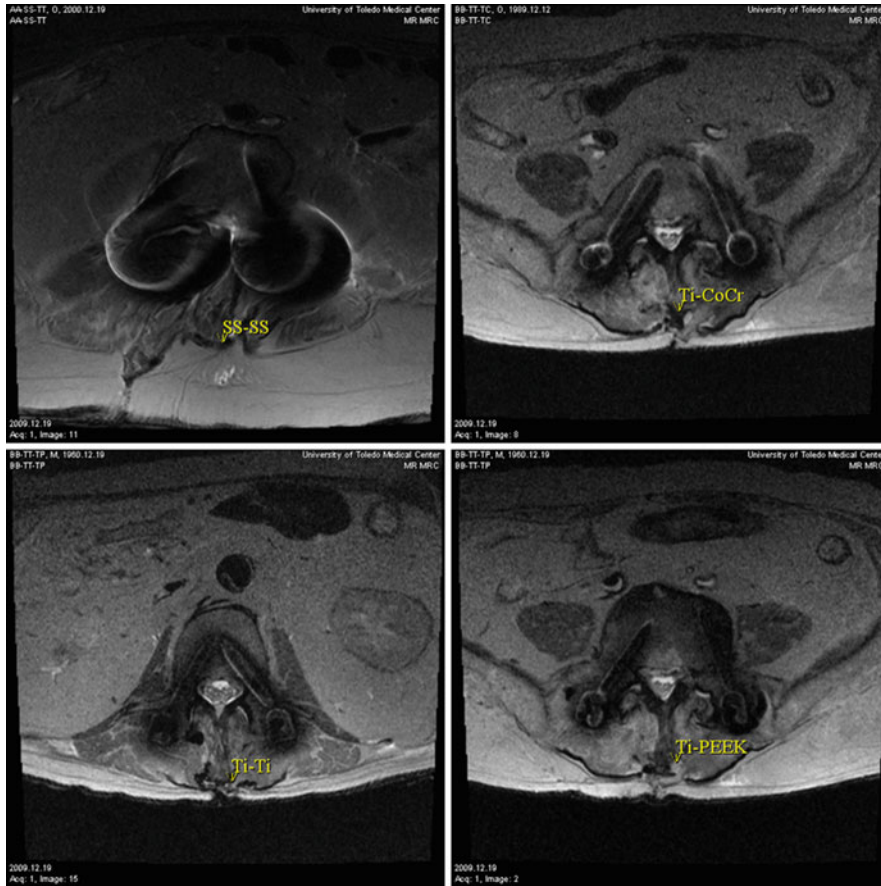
1.5 T MRI of pedicle screw instrumented and rods
